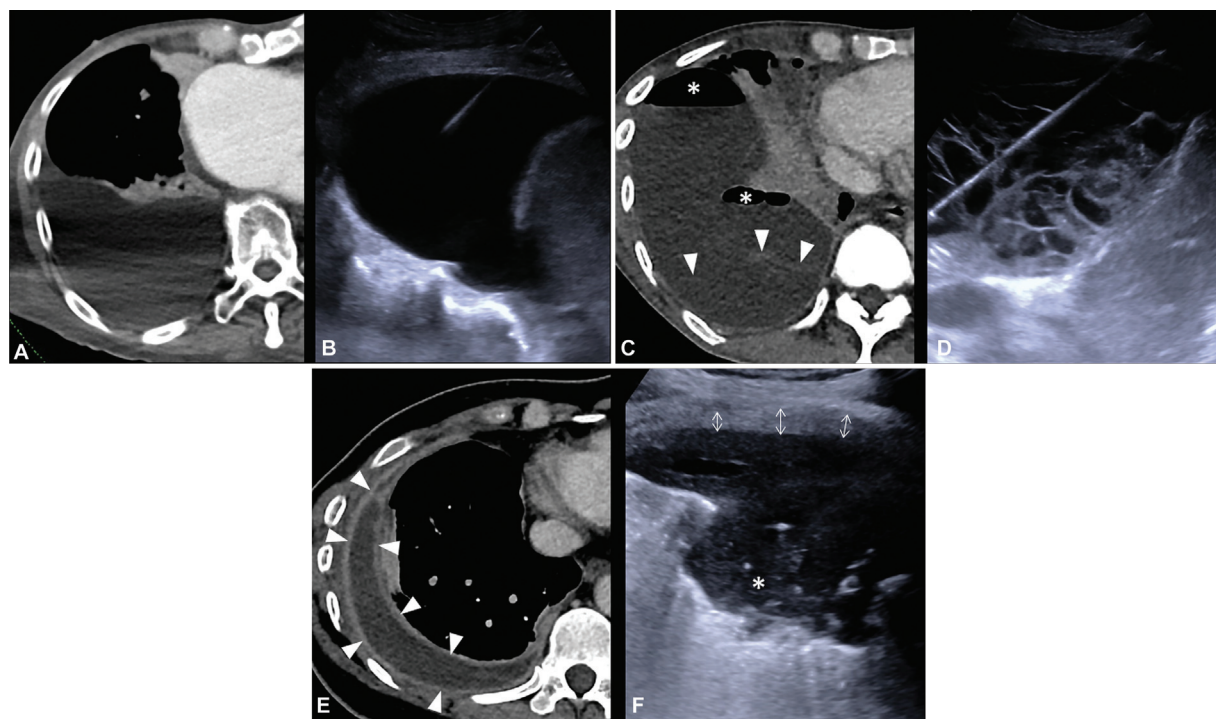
A 78-year-old male patient with heart failure, pneumonia, and a simple effusion. (A) Computed tomography (CT) image shows a homogenous low-density effusion devoid of internal septations and without wall thickening and/or enhancement. (B) Ultrasound image at time of needle insertion also reveals an anechoic effusion in the pleural space. A 46-year-old male patient with recurrent effusions from lung malignancy. (C) CT image shows faint internal septations (arrowheads) resulting in a multiloculated effusion. Locules of gas (asterisk) were from a previous procedure. (D) Ultrasound image reveals more conspicuous septations. A needle has been inserted to traverse several locules for better drainage. A 50-year-old lady with tuberculous infection and empyema. (E) CT image shows an effusion with thickened and enhancing walls (arrowheads). (F) Ultrasound image confirms wall thickening (double arrows) as well as dependent echogenic contents (asterisk).
